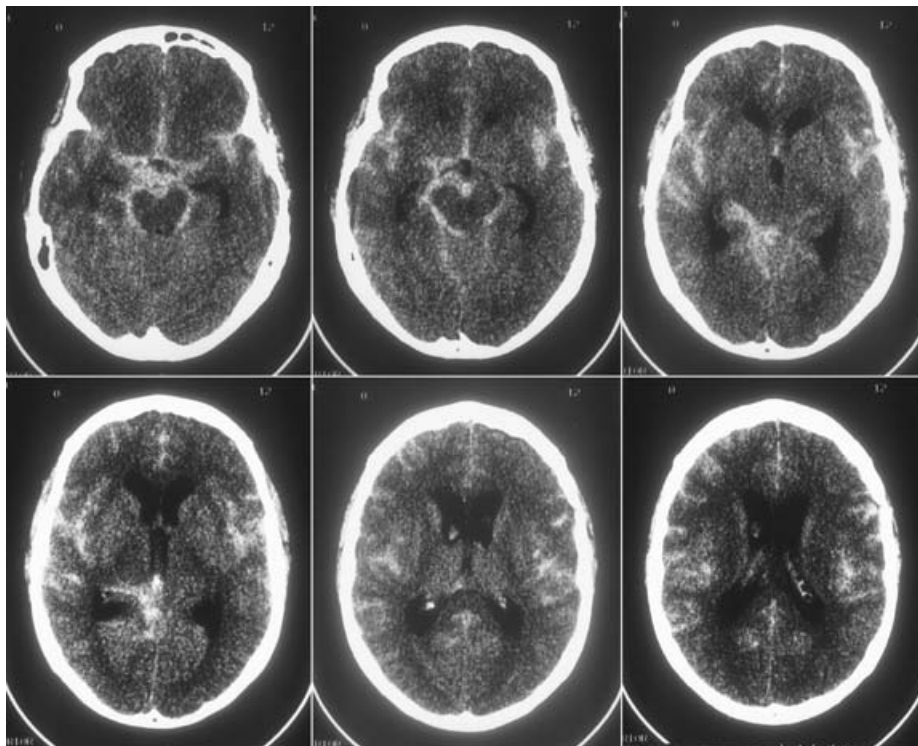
Head CT scan from patient.
